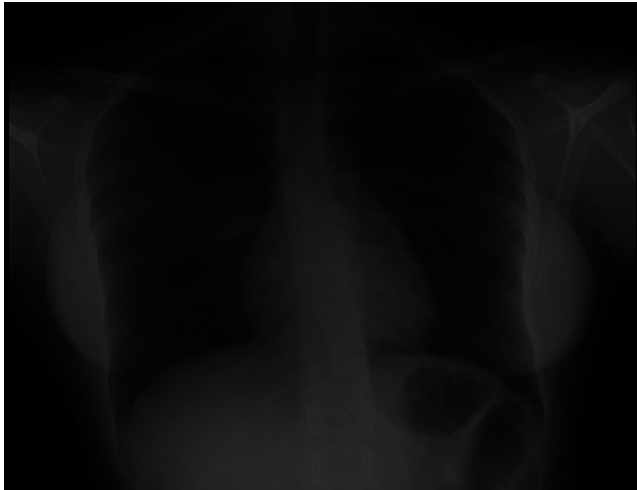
Image of the patient's chest X-ray
